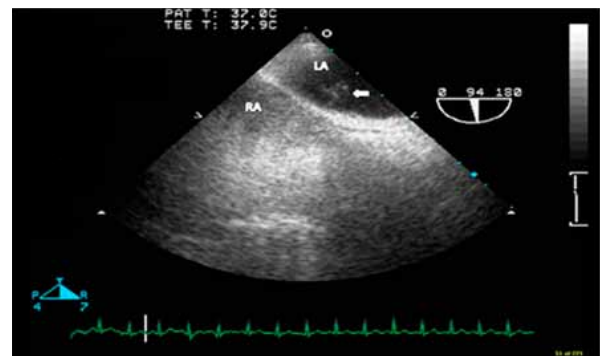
This transesophageal echocardiogram (with bubble study) in the longitudinal plane shows complete opacification of the right atrium (RA) and the passage of a cloud of bubbles (arrow) from the right atrium (RA) to the left atrium (LA), indicating a patent foramen ovale.
